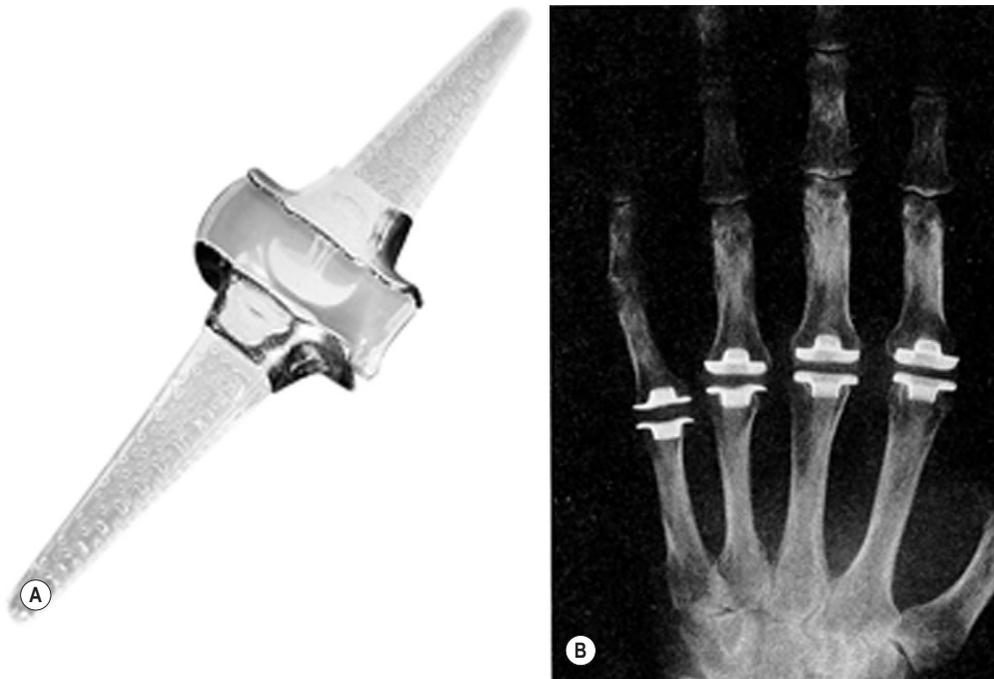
Swanson finger replacement and the appearance on X-ray. (Reproduced by kind permission of Adam C. Gaines, Wright Medical Technology, TN, USA.)
